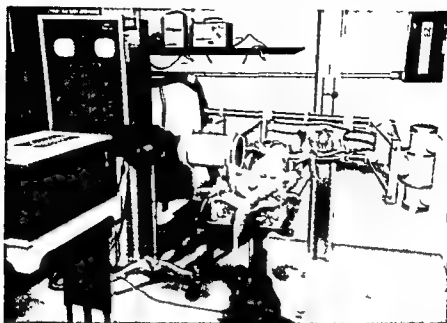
Equipment used for high speed cinefluorography high speed movie camera a six inch Philips image amplifier the electronics for medicine multichannel oscilloscope and recorder a Tektronix 502 dual beam oscilloscope and roentgen ray equipment
